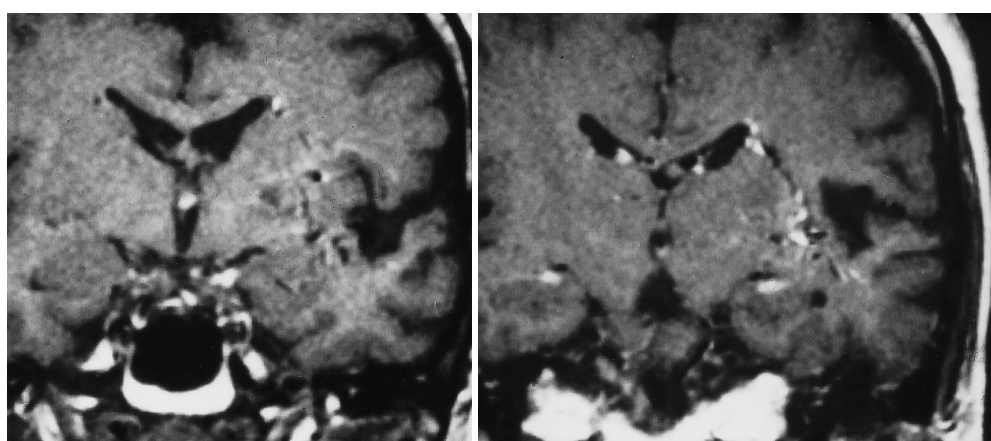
MRI 8 months after Fig. 2. a Coronal T1-weighted image: there has been a decrease in signal intensity in the draining vein, indicating recanalisation. b Contrast-enhanced image demonstrates reduction in size of the lumina of all the atypical veins, compatible with recanalisation of the draining vein
